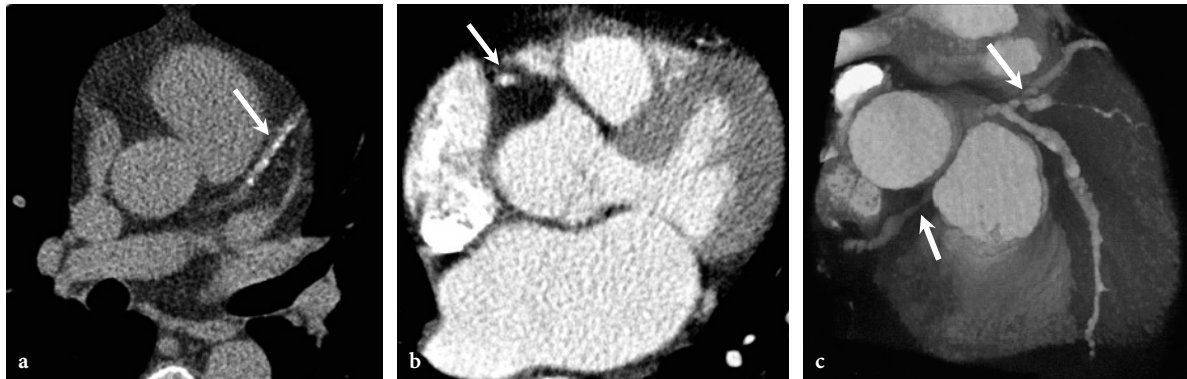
Electron-beam CT acquisition allows the display of coronary calcification in a transaxial image planes and b, c coronary CT angiography. Transaxial image slices of coronary CT angiography by EBCT are compromised due to limited signal-to-noise-ratio (b). 3D display (3D volume rendering) for visualization of the coronary arteries is possible in selected cases (c). Severe LAD and RCA stenoses (*arrows in c*) can be detected in proximal coronary segments. (Images courtesy of (a, b) Klinikum Grosshadern, Munich, Germany and (c) Erasmus University Rotterdam, Netherlands)
